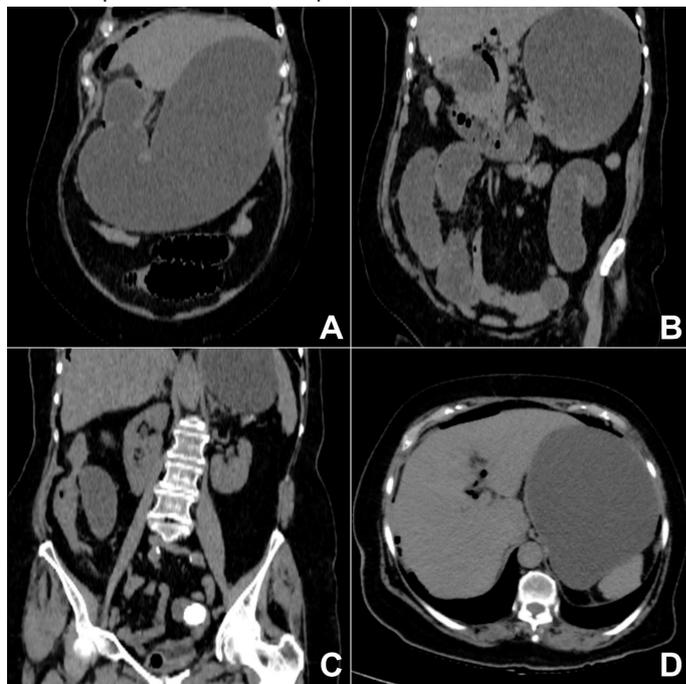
CT findings: (A) Coronal view. Significant gastric distension. (B) Coronal view. Pneumobilia. (C) Coronal view. Gallstone at the level of the small intestine. (D) Axial view. Free air in the abdominal cavity and pneumobilia.
